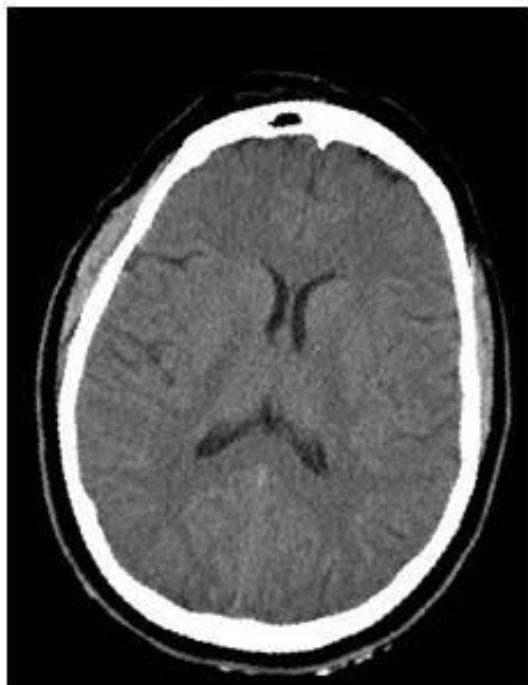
Selected CT slices after the convexity inspection
